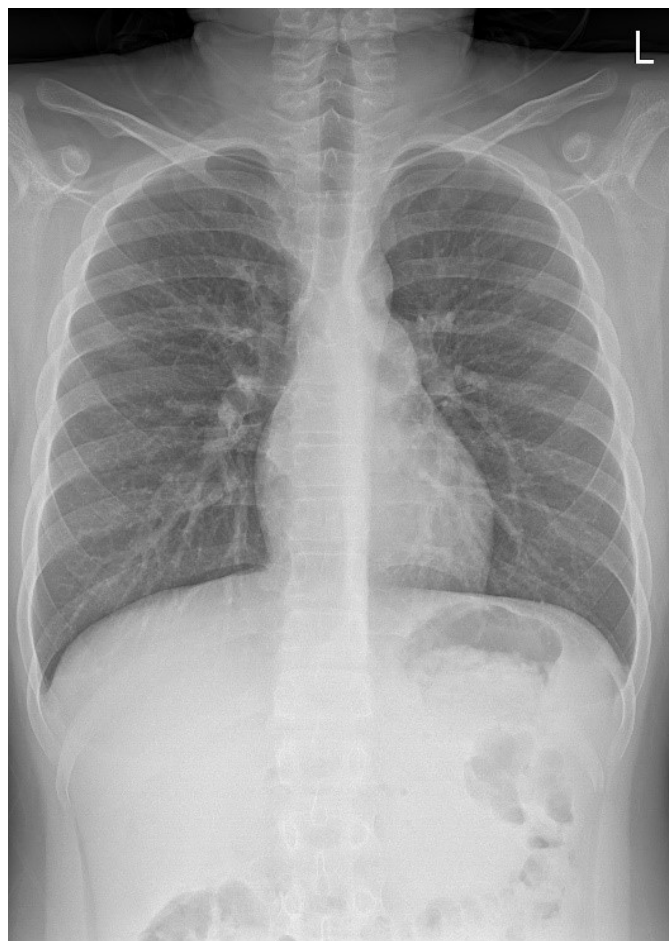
Postoperative chest X-ray after congenital diaphragmatic hernia repair shows a clean contour of the diaphragm and normal parenchyma of the lung.
